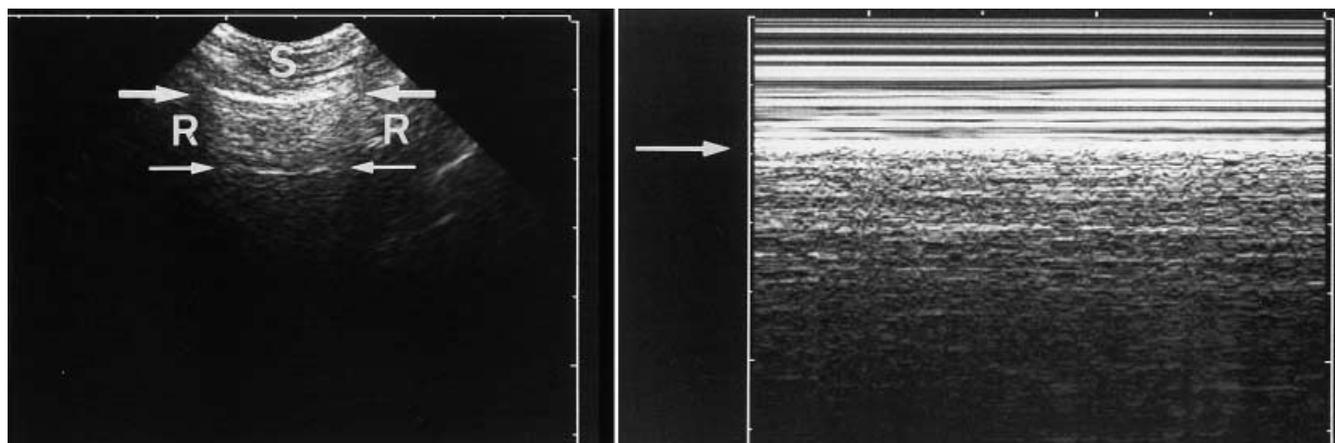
Lung sliding (ultrasound, longitudinal scan, third intercostal space, normal subject). *Left*: real-time. Superficial layers (*S*), shadow of ribs (*R*), pleural line (*large arrows*), roughly horizontal hyperechogenic line (“A line”) (*fine arrows*). Lung sliding cannot appear on this frozen view. *Right*: time-motion. This mode allows materialization of the lung sliding. The superficial layers yield a horizontal pattern, as they remain motionless. From and below the pleural line (*arrow*), the pattern appears granulous, as the motion of the pleural line is reflected all over this area
